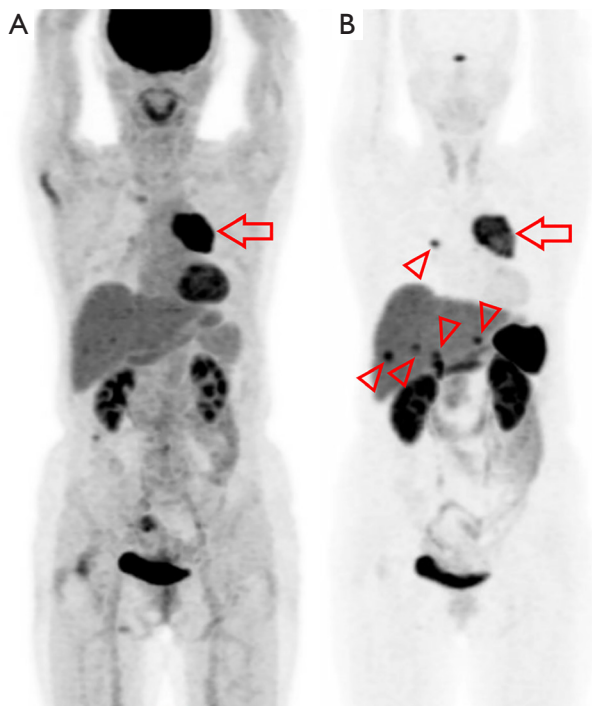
Case 4: a female in her seventies was evaluated by two nuclear medicine examinations. (A) FDG-PET (maximum intensity projection image); (B) ^{68}Ga DOTATOC-PET (maximum intensity projection image). FDG-PET demonstrated intense uptake at the anterior mediastinal mass (A, arrow), albeit without definitive uptake elsewhere. ^{68}Ga -DOTATOC PET revealed intense uptake not only in the anterior mediastinal mass (B, arrow), but also in the right lung hilum and liver, which strongly suggests multiple metastases (B, arrowheads). FDG, fluorodeoxyglucose; PET, positron emission tomography; ^{68}Ga , 68-gallium.
